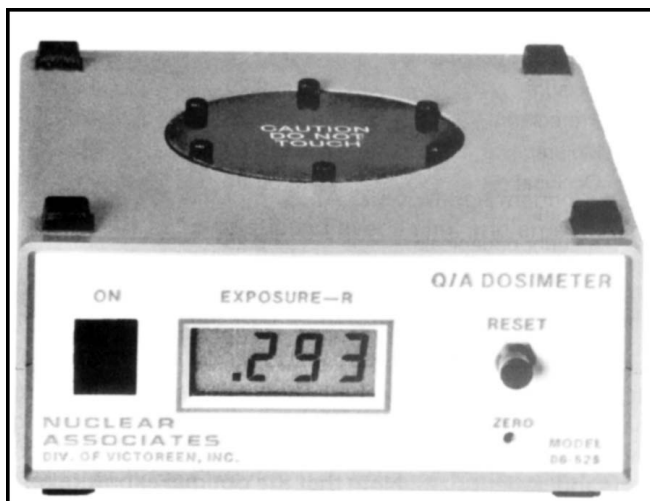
Device for measuring exposure of an X-ray machine. The aiming cylinder of the X-ray machine is positioned on the center of the top and an exposure made. The display on the front gives the output in Roentgens
